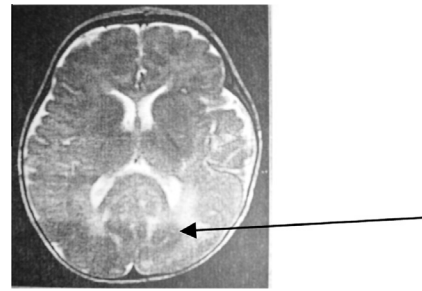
Brain MRI of Case 7 showed irregular high signal intensity involving the white matter of both occipital and peritrigonal regions on the T2WIs(Arrow).
